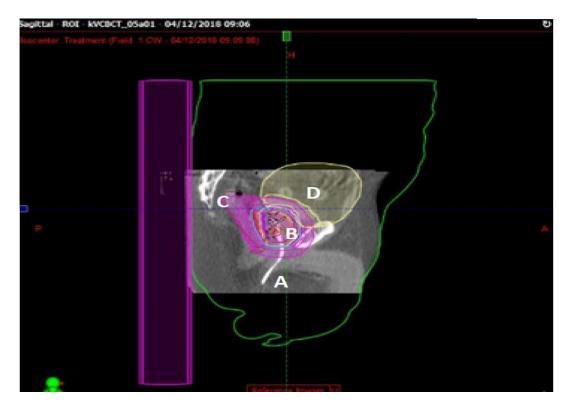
RayPilot[®] CBCT imaging - sagittal CBCT showing placement of the transmitter cable (A), the transmitter tip (B), the outlined rectal volume (C- outlined in red) and the outlined bladder volume (D - outlined in yellow). The corresponding colour wash outlines depict the high dose target volume and expected dose delivered to the surrounding tissues.
